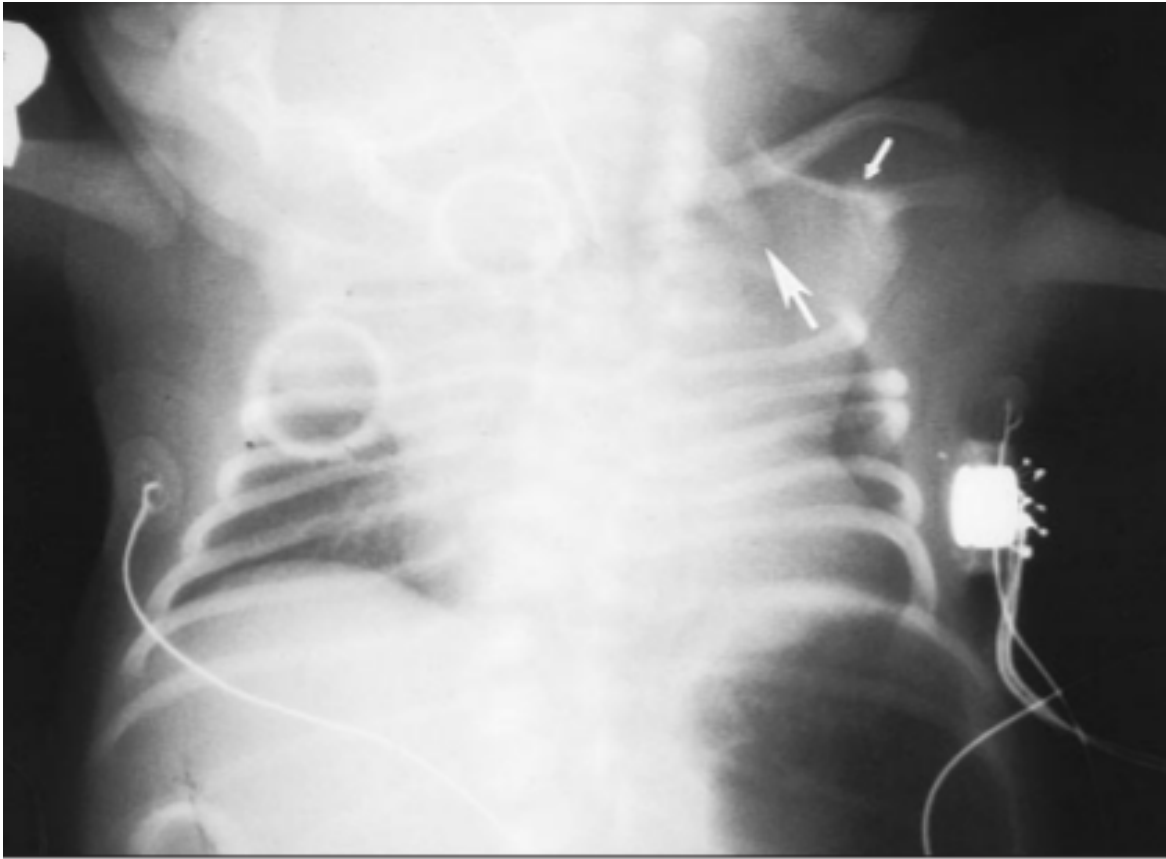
Frontal chest postnatal radiograph showing the elevated left scapula (short arrow) and the omovertebral bone (long arrow) interposed between the superior scapula and the cervical spine. Also note the scoliosis, multiple thoracic vertebral segmentation abnormalities, and multiple hypoplastic upper left ribs
